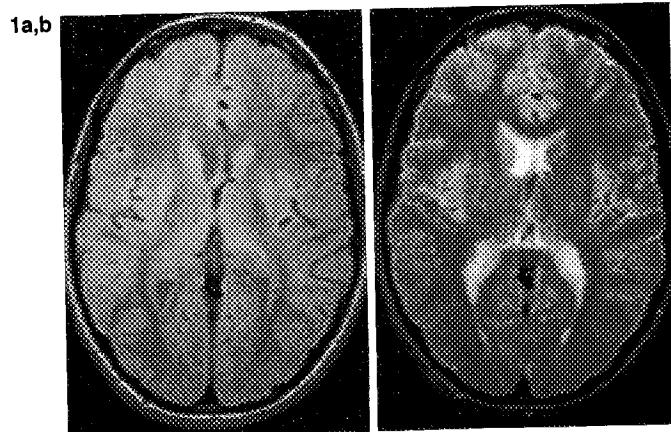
Representative MR brain image slices: proton density image slice (a); T2-weighted image slice (b).
